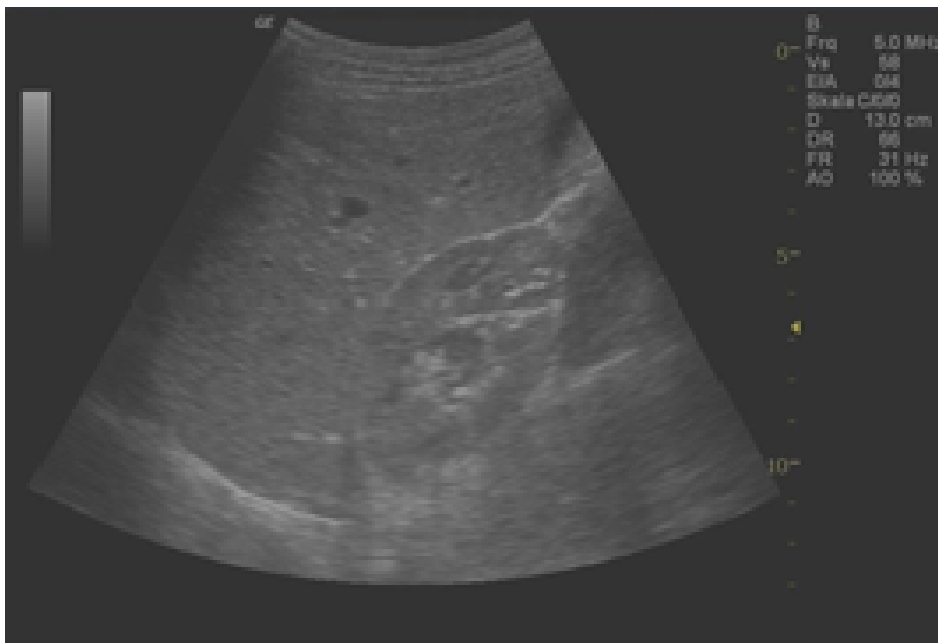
Ultrasound-picture of the liver and right kidney: Echogenicity and liver steatosis can be analysed.
